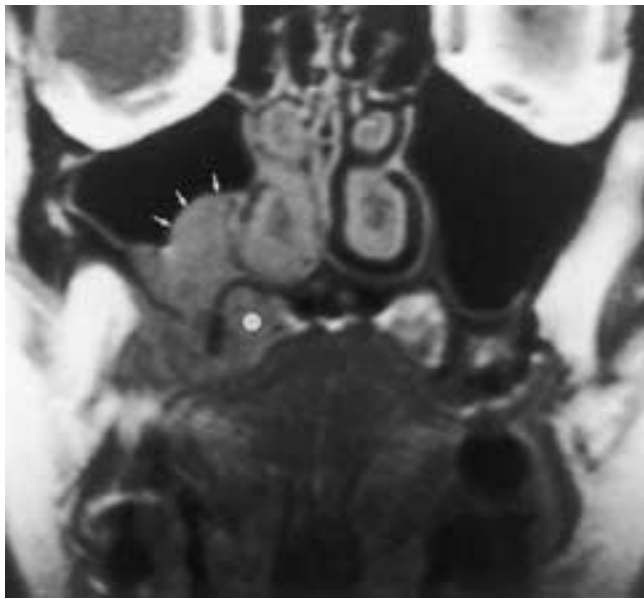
Adenoid cystic carcinoma of the hard palate. Coronal T1-weighted MR image demonstrates replacement of the normal high signal intensity of the minor salivary gland tissue in the right aspect of the hard palate (*white dot*). Normal salivary glands are identified on the left. This tumor has eroded the inferior aspect of the right maxillary sinus and has an intrasinus component (*arrows*).
